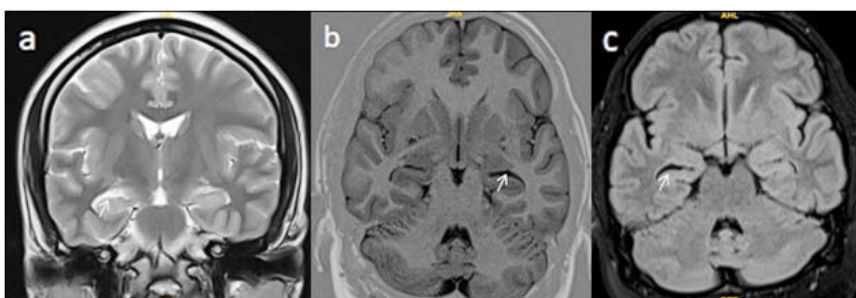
(a) T2 coronal, (b) T1 inversion recovery oblique Coronal, (c) FLAIR oblique coronal showing loss of striations on the right side with loss of volume in right hippocampus
